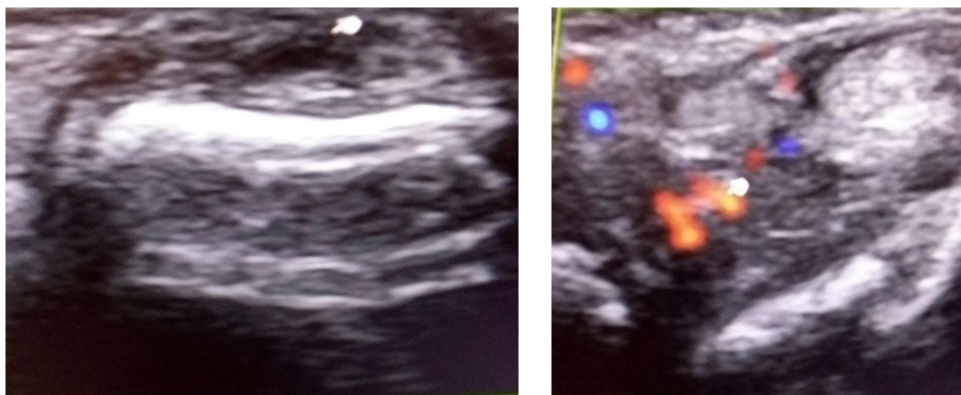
USG power doppler study of hand joints shows right radio ulnar & 2nd MCP synovitis with mild hyperaemia and joint erosion.
